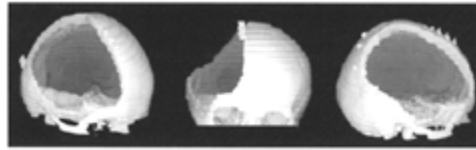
“Three-D-reconstruction of CT imaging of a large craniectomy in three different angles.
